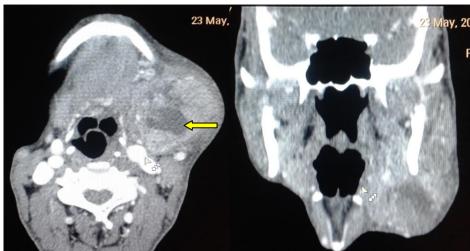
Submandibular gland carcinoma with necrotic node. Contrast CT of neck shows heterogeneously enhancing mass in left submandibular gland with necrotic cervical station IB node.
